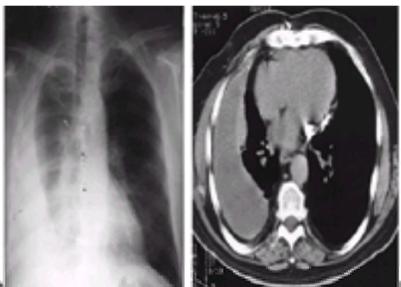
Images of the radiologic examination of a patient with a fibrothorax on the basis of chronic empyema. (A) Posteroanterior view of the chest radiograph demonstrating the extensive nature of the pleural involvement. Linear calcification can be seen on the right at the base of the pericardium. (B) The chest CT scan at the level of the heart again demonstrates the extensive pleural disease, and pericardial calcification can be seen.
